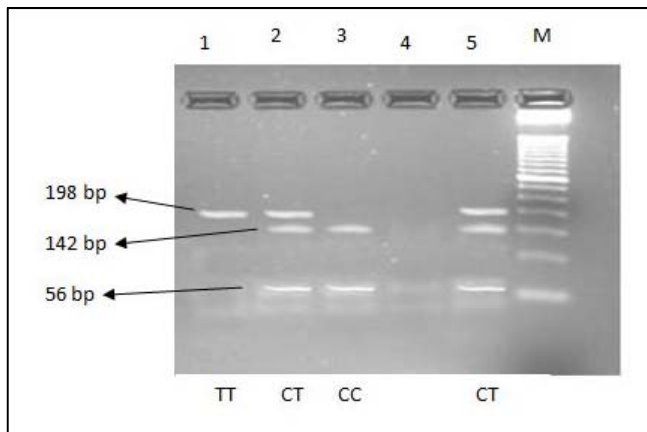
Identification of AdipoR1 polymorphism RS 2275738: MSLI restriction fragments. Lane no. 3 was homozygous wild type (genotyped CC) (142 bp, 56 bp), lanes no. 2 & 5 were heterozygous mutant (genotyped CT) (198 bp, 142 bp, 56 bp) and lanes no. 1 was homozygous mutant (genotyped TT) (198 bp). M, 50 bp DNA ladder.
